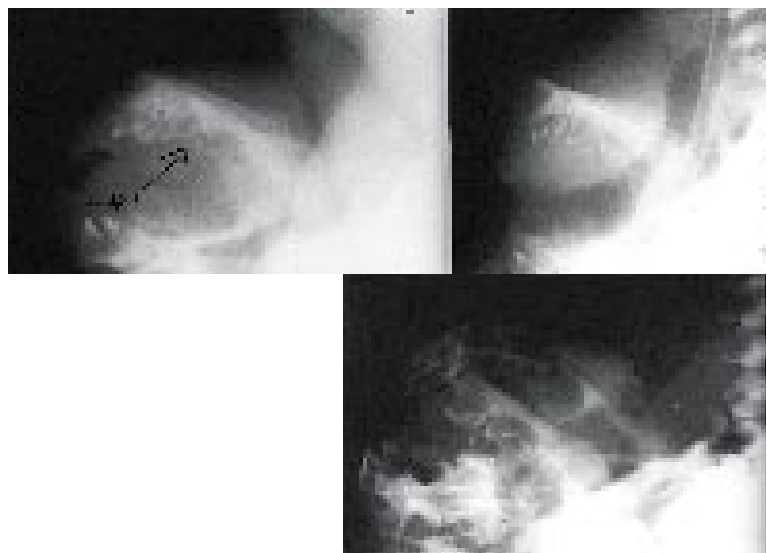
The presence of teeth seen by radiography in the jaw is a relatively accurate method of assessing gestational age. In the figure on the top left, incisors and cuspids have appeared but no molars, indicating a gestational age of less than 33 weeks. In the top right is shown the appearance of incisors and first deciduous molars consistent with 33 to 37 weeks gestation. On the bottom, the second deciduous molar and follicle of first permanent molar are present, indicating a gestation of greater than 37 weeks. This method is not useful in assessing infants with anhydrotic ectodermal dysplasia who have adentia.
